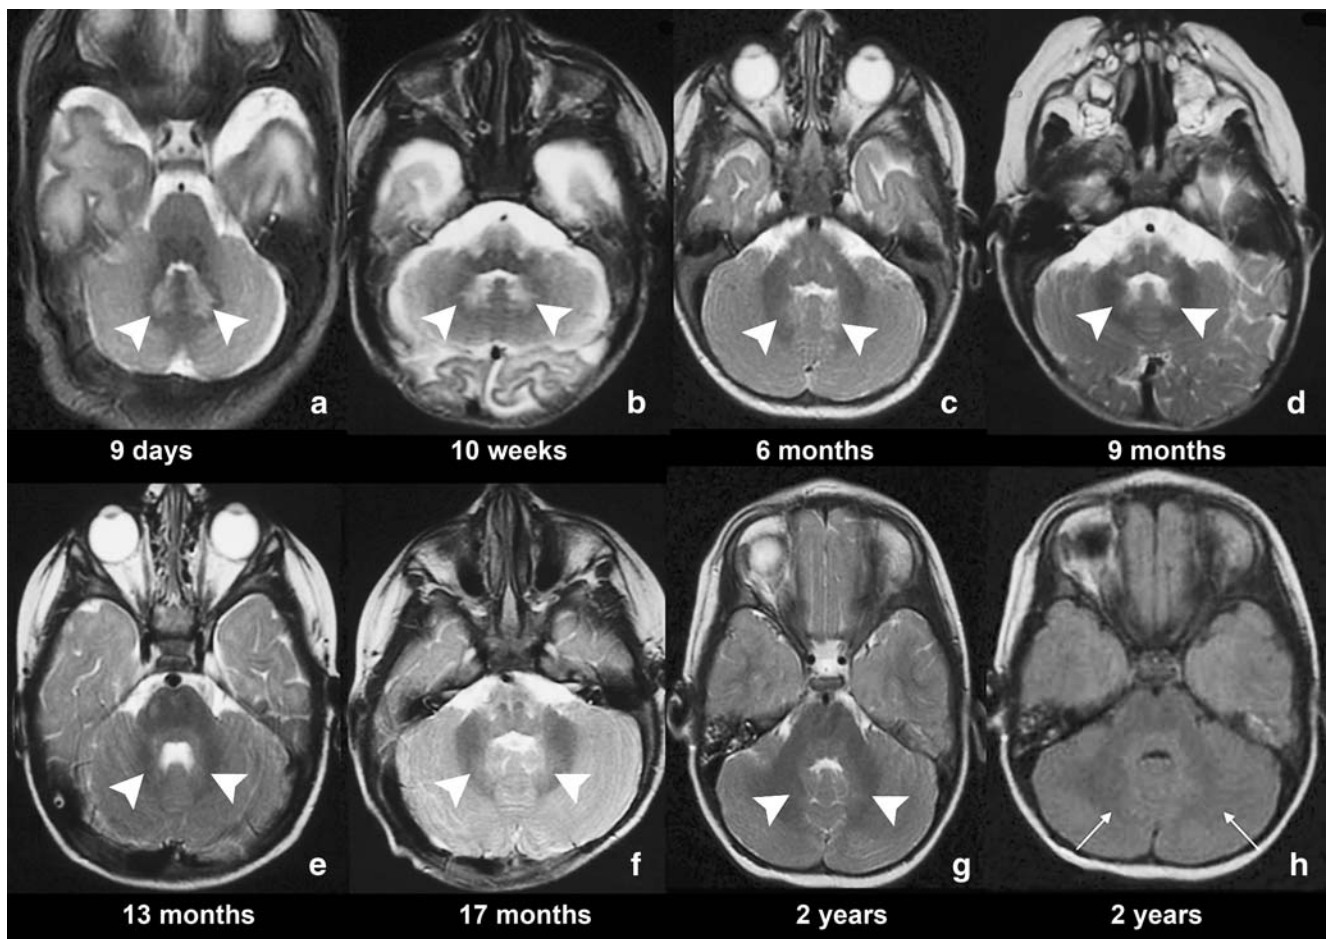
Normal appearance of the dentate nucleus. a–g Axial T2-W imaging from birth to year 2 of life shows the dentate nuclei (*arrowheads*). h FLAIR image in a 2-year-old child. The dentate nucleus remains somewhat distinguishable from the peridentate white matter (*arrows*)
